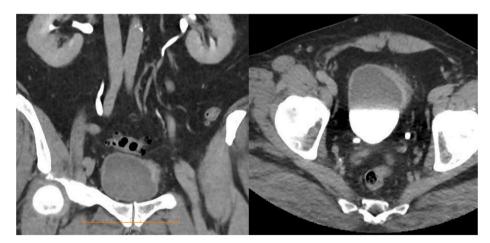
CT IVP performed 12 months after initial diagnosis (after intra-vesical BCG and several cysto-biopsies). Non-specific focal thickening of the left lateral wall is seen.
